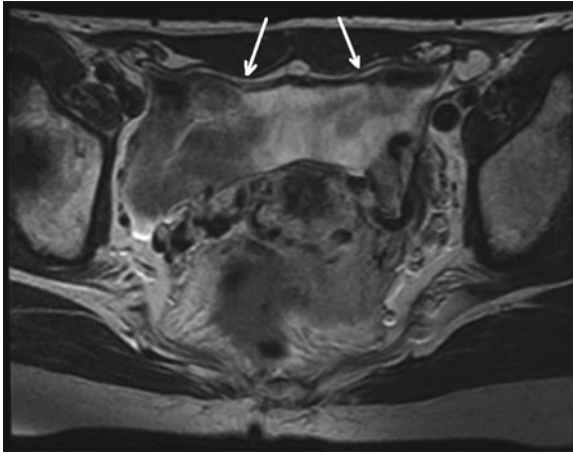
MRI pelvis T2 axial image. Bilateral inguinal mesh found to be in appropriate position (*white arrows*).
